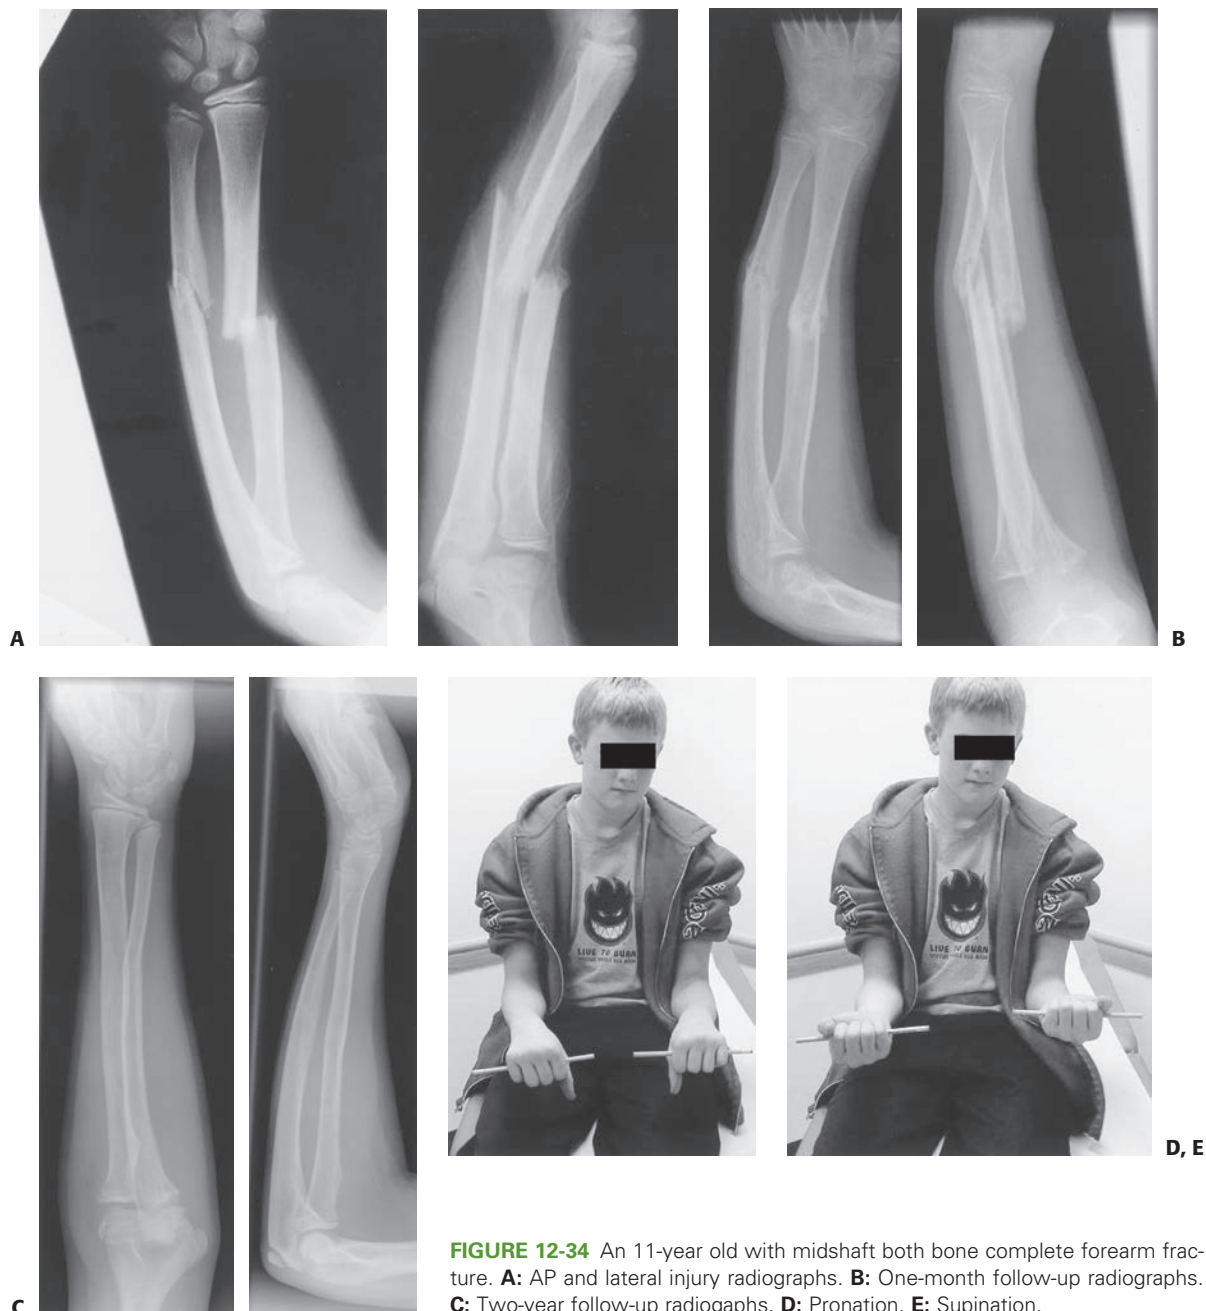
An 11-year old with midshaft both bone complete forearm fracture. A: AP and lateral injury radiographs. B: One-month follow-up radiographs. C: Two-year follow-up radiographs. D: Pronation. E: Supination.
